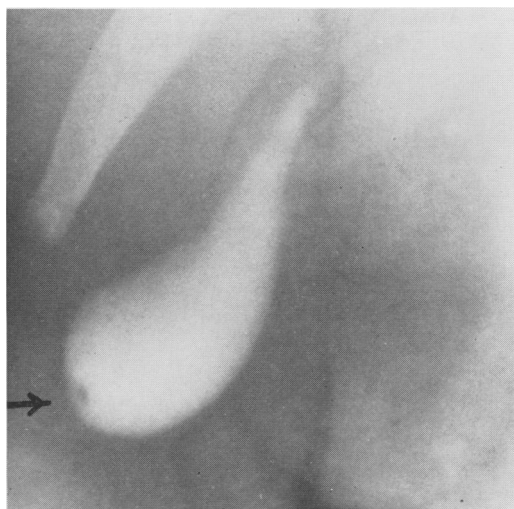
Roentgenogram of gallbladder in contracted phase shows defect in fundus due to adenomyoma of gallbladder.
